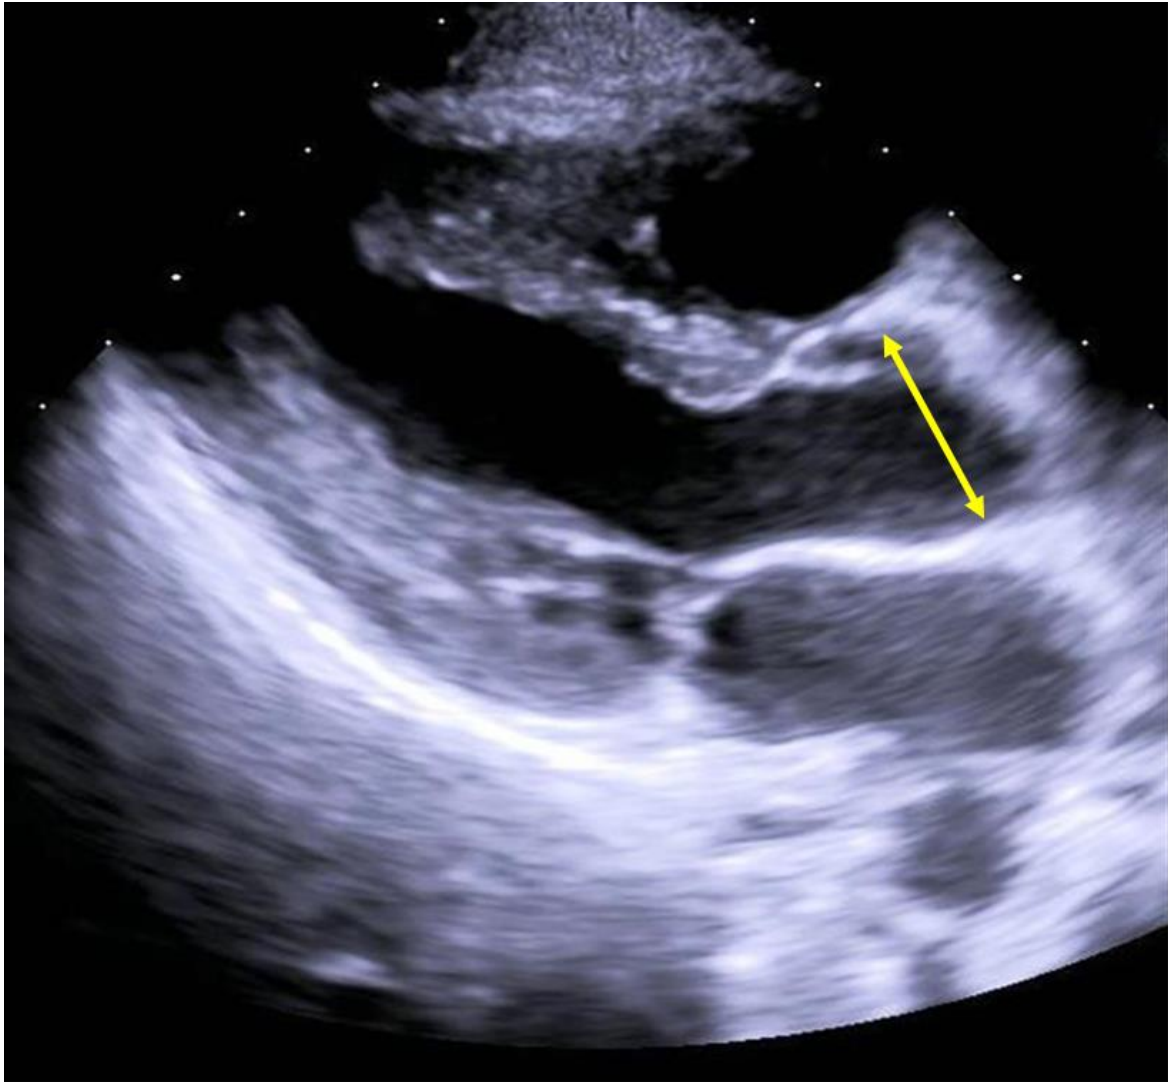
Aortic diameter measurements obtained just proximal to the aortic root at the tip of the aortic valves (yellow arrow) when in the open position in the outflow tract in the parasternal long axis view (Mitchell *et al.*, 2010b).
